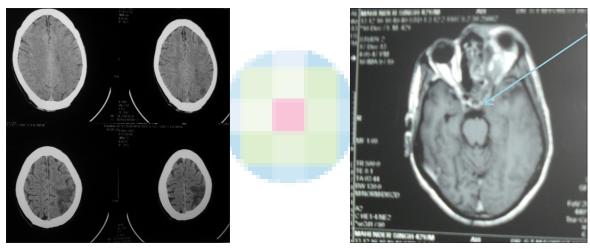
Noncontrast computed tomography head on the second day, showing hypodense area in left middle cerebral artery territory
